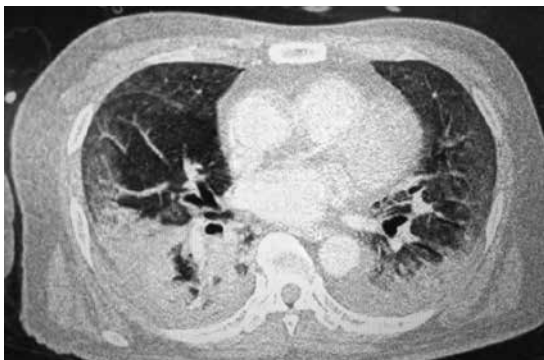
Contrast-enhanced CT on day 16 after admission. Widespread pneumonia image is noted in both lung fields.
